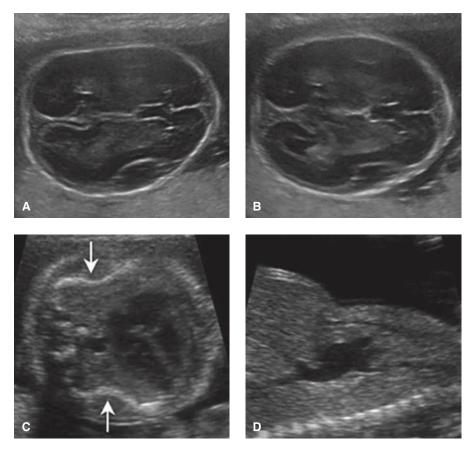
Osteogenesis imperfecta, Type IIa. A. Due to lack of skull ossification, gentle ultrasound transducer pressure on the maternal abdomen results in visible deformation (flattening) of the skull in this 24-week fetus. B. When the transducer pressure is removed, the skull shape returns to normal. C. In the four-chamber view of the heart, in-utero fractures lead to abrupt angulation of the ribs (*arrows*). D. The thorax is markedly smaller than the abdomen in this sagittal image.
